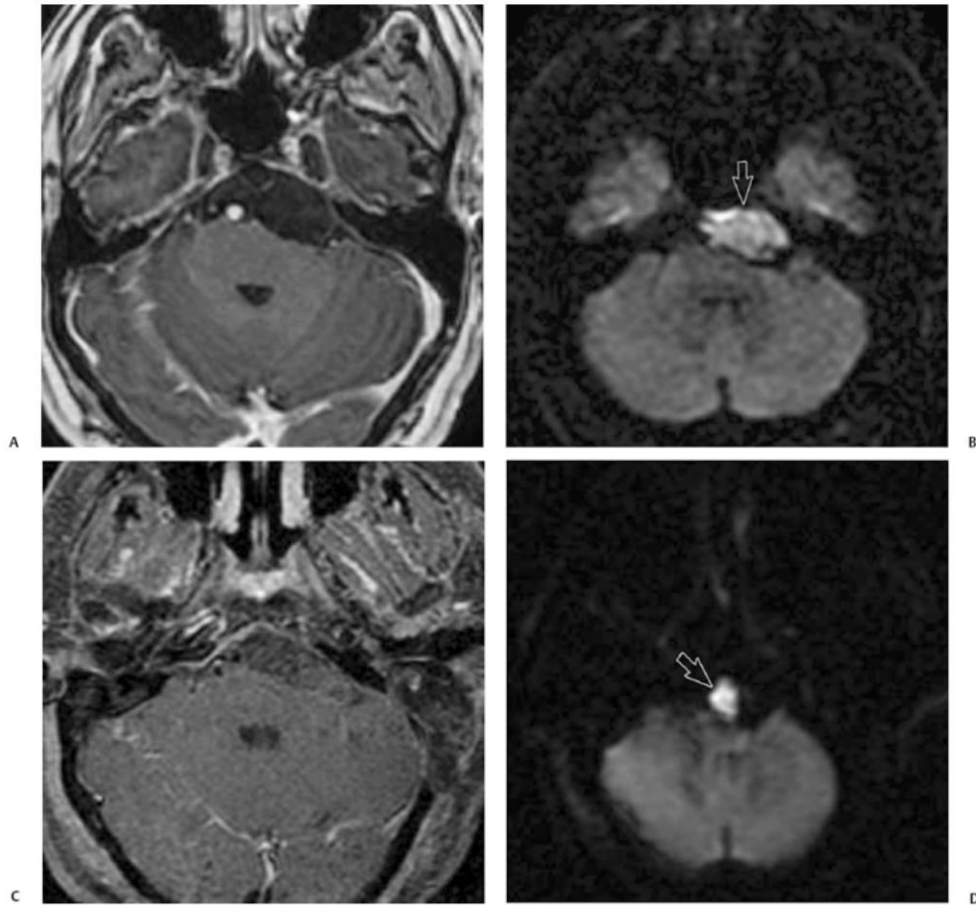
Epidermoid. (A) Preoperative gadolinium-enhanced T1-weighted magnetic resonance image (T1WI). (B) Diffusion weighted image shows a preponine epidermoid tumor with characteristic restricted diffusion. (C) Gadolinium-enhanced T1WI performed following subtotal surgical resection shows heterogeneous signal, and residual tumor cannot be distinguished from postoperative changes. (D) Diffusion weighted imaging confirms residual epidermoid, seen as focal high signal intensity.
